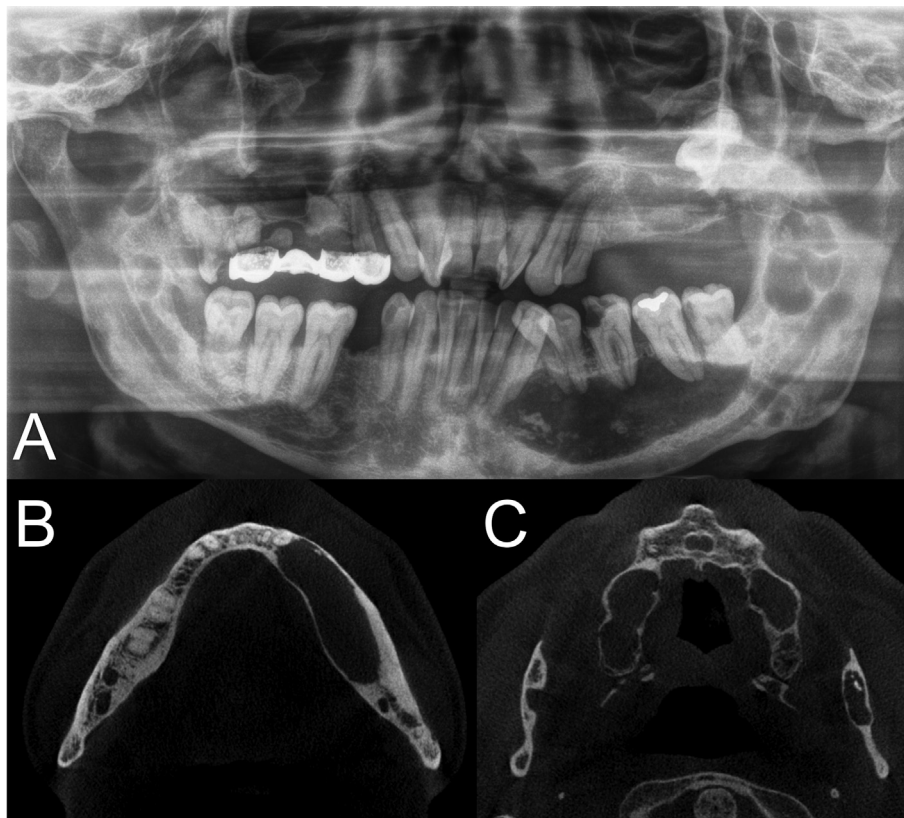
OPG (A), CBCT axial slice (B,C) of a patient with NBCCS. Note the non-expansive cystic lesions at the CBCT slices and the maxillary left third molar that is impacted in the maxillary sinus due to a OK.
